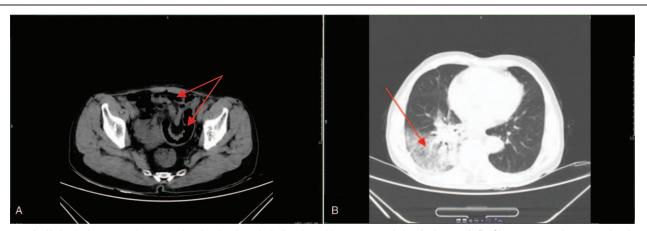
A. Abdominal computed tomography showing intestinal dilatation with gas accumulation (red arrows); B. Chest computed tomography showing consolidation of the right lower lobe (red arrow).
